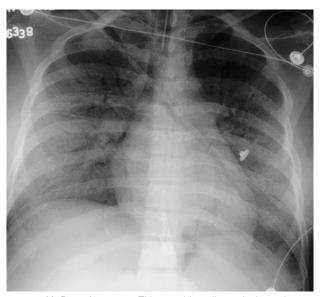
Air Bronchograms. This portable radiograph shows increased density throughout both lungs highlighted by tubular lucencies. These are air bronchograms. They are visualized because of the alveolar filling that surrounds them. This typical alveolar filling pattern (airspace disease) suggests acute pneumonia, pulmonary hemorrhage, or pulmonary edema.
